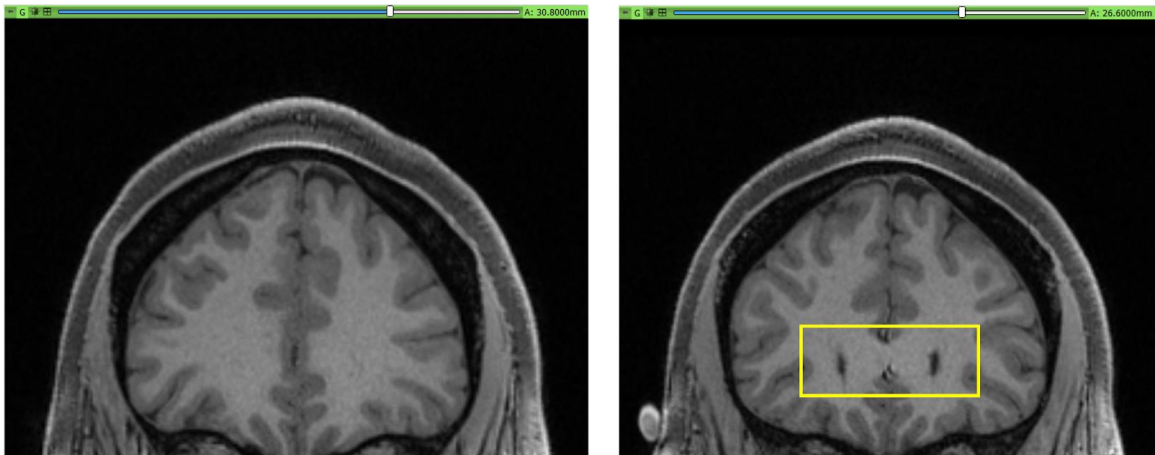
MRI Displaying Opening of Anterior Horn. Moving posteriorly, the anterior horn is marked by a break in the white matter (yellow box) just after the merging of the right and left hemisphere's white matter, which is the corpus callosum.
